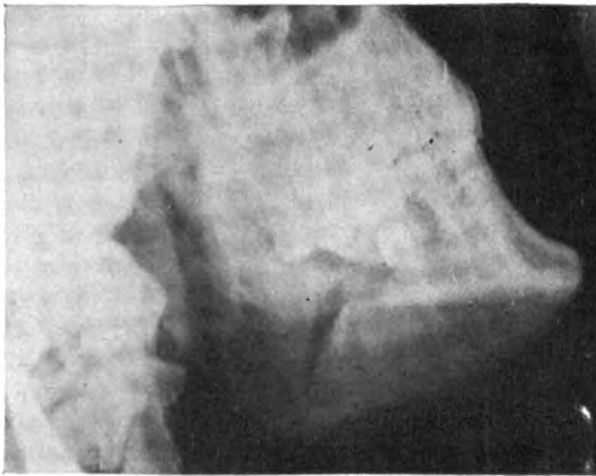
Lateral roentgenogram showing compound fracture of mandible in second molar area, with upward displacement of posterior fragment. Contact of ramus with maxillary tooth can be seen. Mesial root of lower molar remaining in line of fracture.*
